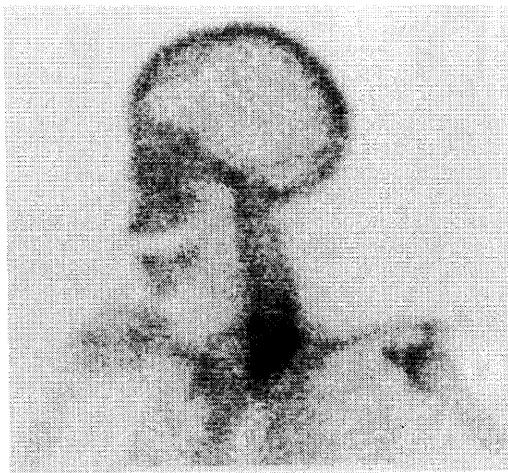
Left anterior oblique image of a bone scintigram obtained 3 hours after 99 mTc-MDP 740 MBq intravenous injection demonstrates intense radionuclide accumulation in the left lower neck corresponding with calcified lesions.
